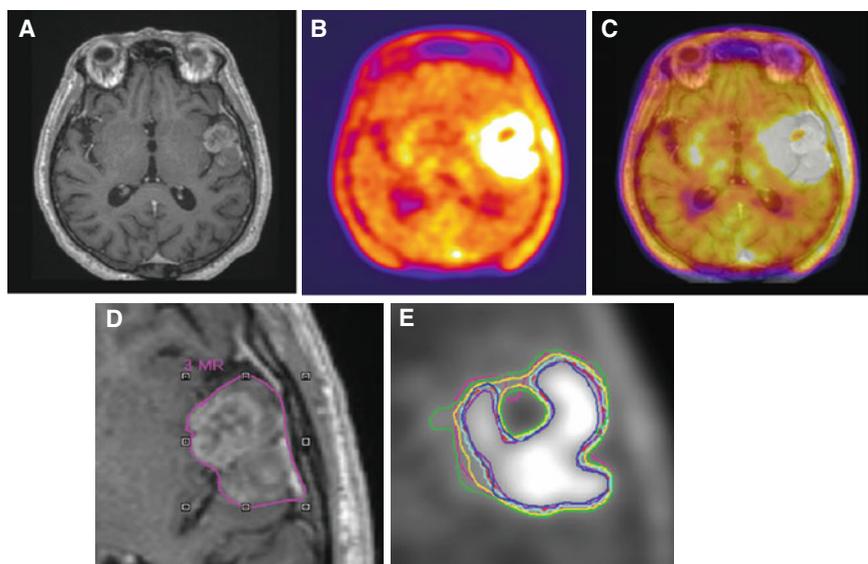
(A) Gadolinium enhanced T1-weighted MRI, (B) corresponding ^{18}F -FET PET, and fused PET/MR (C) transaxial slices of a clinical study with a glioblastoma showing differences in target-volume definition. Indicated are (D) the gross tumour volume (GTV) delineated on MRI ($\text{GTV}_{(\text{MRI})}$), and (E) enhanced details of PET-based GTVs obtained by manual delineation of contours ($\text{GTV}_{(\text{man})}$; magenta), an isocontour of a standardized uptake value (SUV) of 2.5 ($\text{GTV}_{(2.5)}$; purple), a fixed threshold
